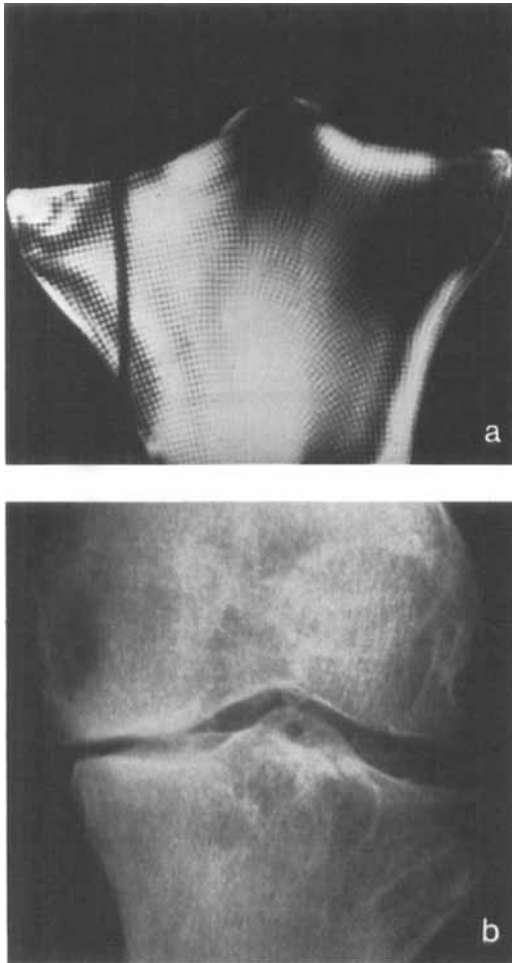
A photoelastic study of a tibia with asymmetric loading on the joint surface shows the stress trajectories centred in the loaded condyle, whereas a repulsive, singular point may be seen in the contralateral condyle (a). In conformity with this, X-rays show a condensed bony structure in the loaded tibial condyle and a relative thinning of the structure in the unloaded condyle (b).
